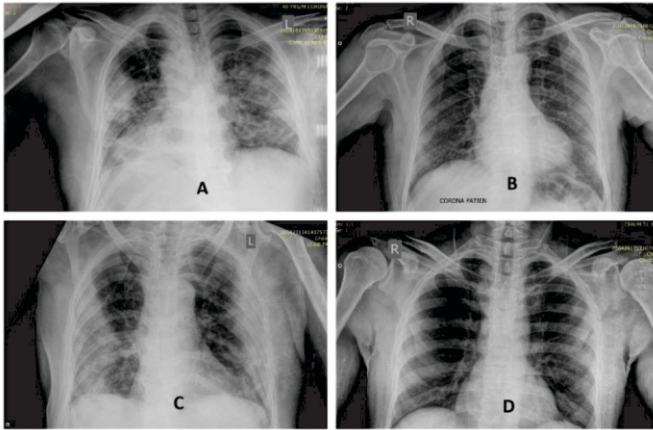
Chest radiograph findings in non-critical patients : A - right peripheral consolidation and left peripheral ground glass haze, B - left peripheral ground glass haze, C - bilateral peripheral consolidations, D - bilateral peripheral ground glass haze.
